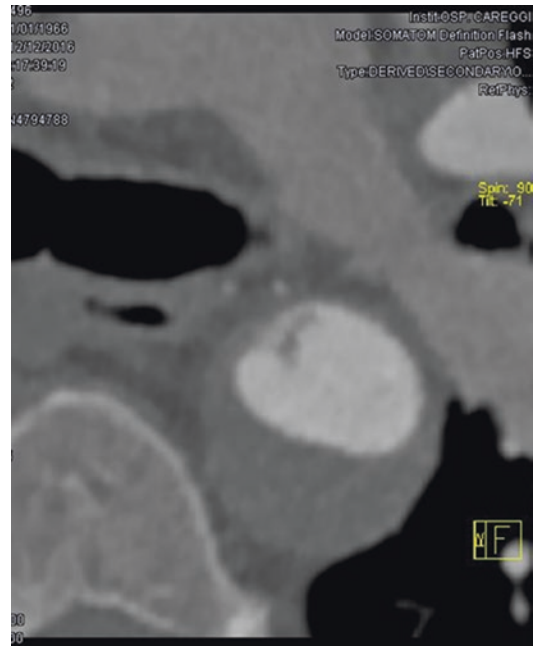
Contrast-enhanced thoracic multidetector CT (MDCT) scan of a patient with blunt trauma shows hematoma post-isthmus aortic with intimal flap (intramural hematoma plus)
